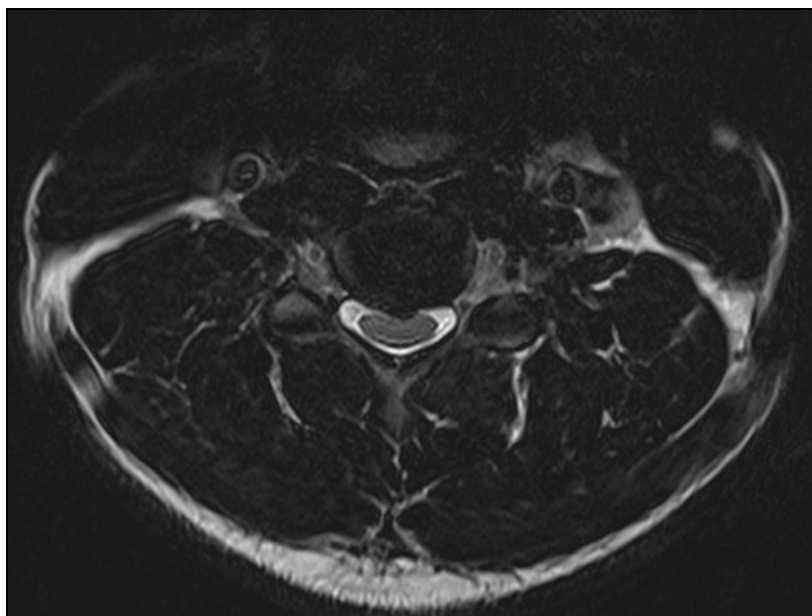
Cervical spinal MRI in axial section T2 Space sequence showing a posteromedial disc herniation discreetly lateralized to the left with spinal cord compression (CNHU-HKM)
